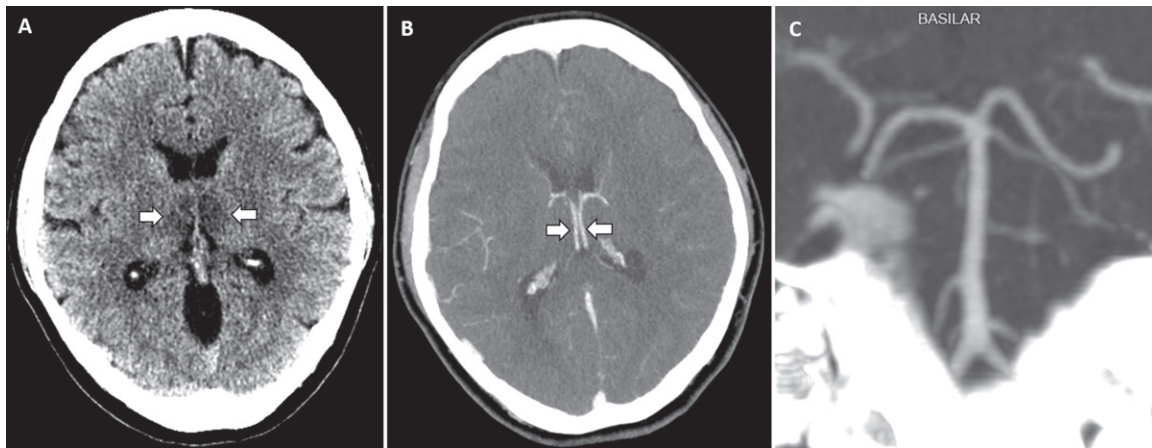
A, Unenhanced CT scan of head demonstrates symmetric low attenuation within the bilateral medial thalami (arrows). B, Axial CT venogram demonstrates patency of the cerebral venous vasculature, including the internal cerebral veins (arrows). C, Coronal reformation of CT angiogram demonstrates normal appearance of the basilar artery and proximal posterior cerebral arteries.
